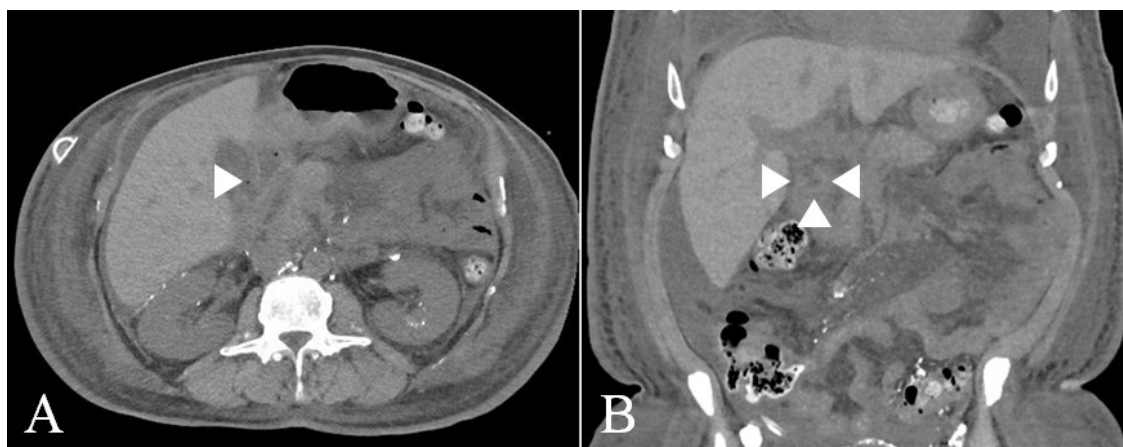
Computed tomography scan of the abdomen on day X. A. Horizontal section shows free air at the side of the duodenal bulb. B. Coronal section shows irregularity of the duodenal wall.
